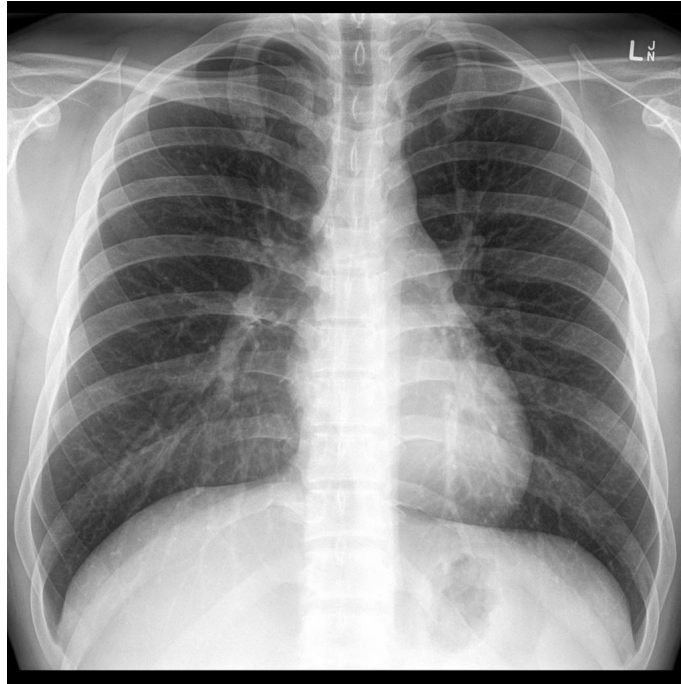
Normal Chest X-Ray
